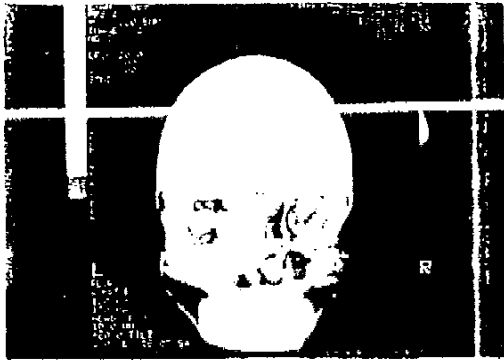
A coronal CT of patient No. 5 showing a lesion in the left ethmoid, nasal cavity, maxillary sinus and the orbit with bone destruction.
